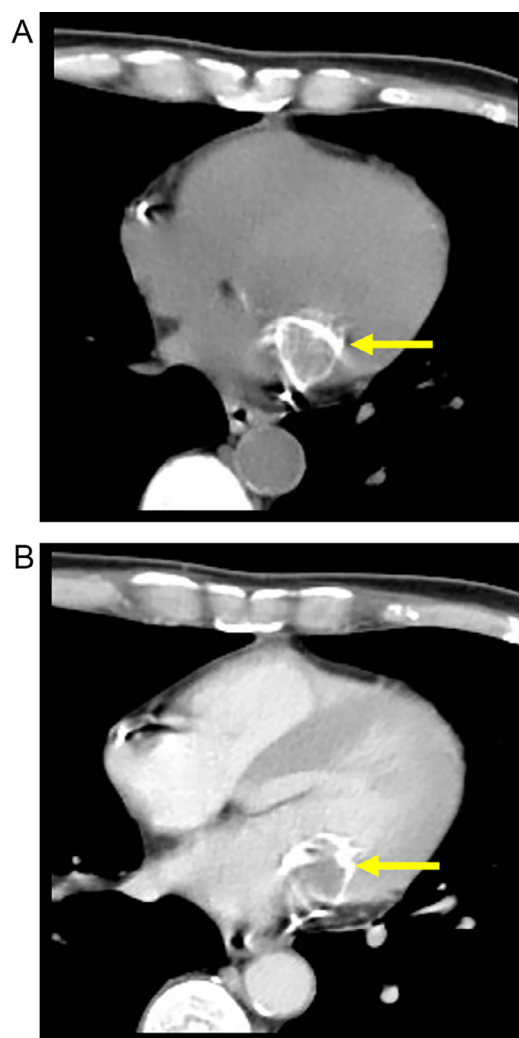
Preoperative contrast CT shows a mass attached to the mitral valve with marginal calcification (A), with no significant contrast enhancement (B).
